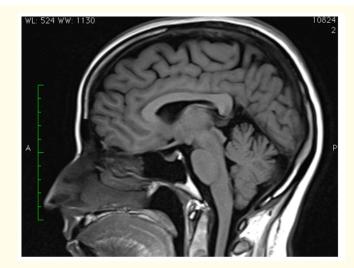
T1 sagittal MRI demonstrates tonsillar herniation (white arrow) and decrease of mamillopontine distance, meaning sagging of the brain.
